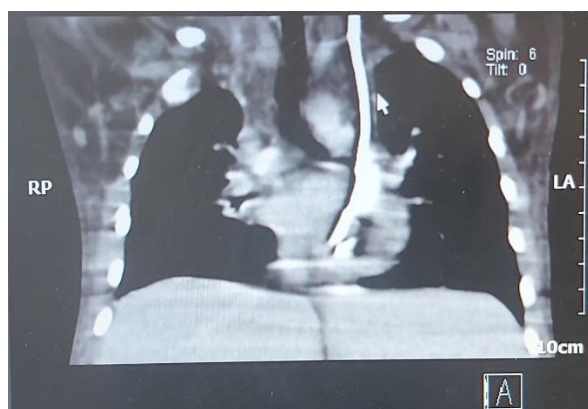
Spiral CT scan of thorax with IV contrast showing persistent left superior vena cava.
